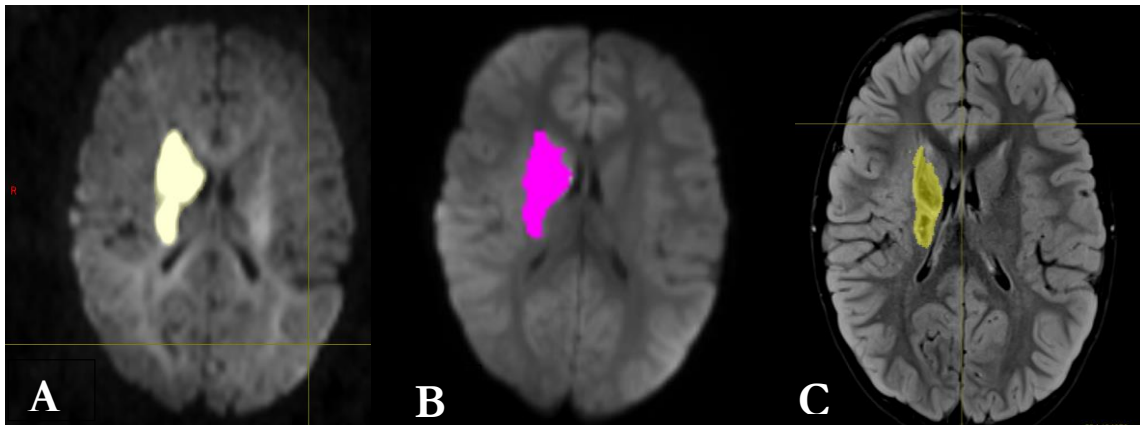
An example of segmentation methods used (A) Manual segmentation of acute infarct volume using DWI (B) Automated segmentation of infarct volume using RAPID (C) Manual segmentation of chronic infarct volume using T2 FLAIR
